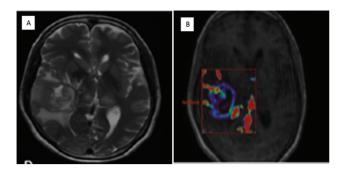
Case of diffuse large B cell lymphoma. T2-weighted imaging reveals a small area of hyperintensity in the genu of the corpus callosum. (A). Percentage signal recovery is high (red curve) on dynamic susceptibility contrast perfusion imaging in lymphoma with mild elevation in relative cerebral blood volume (B).
